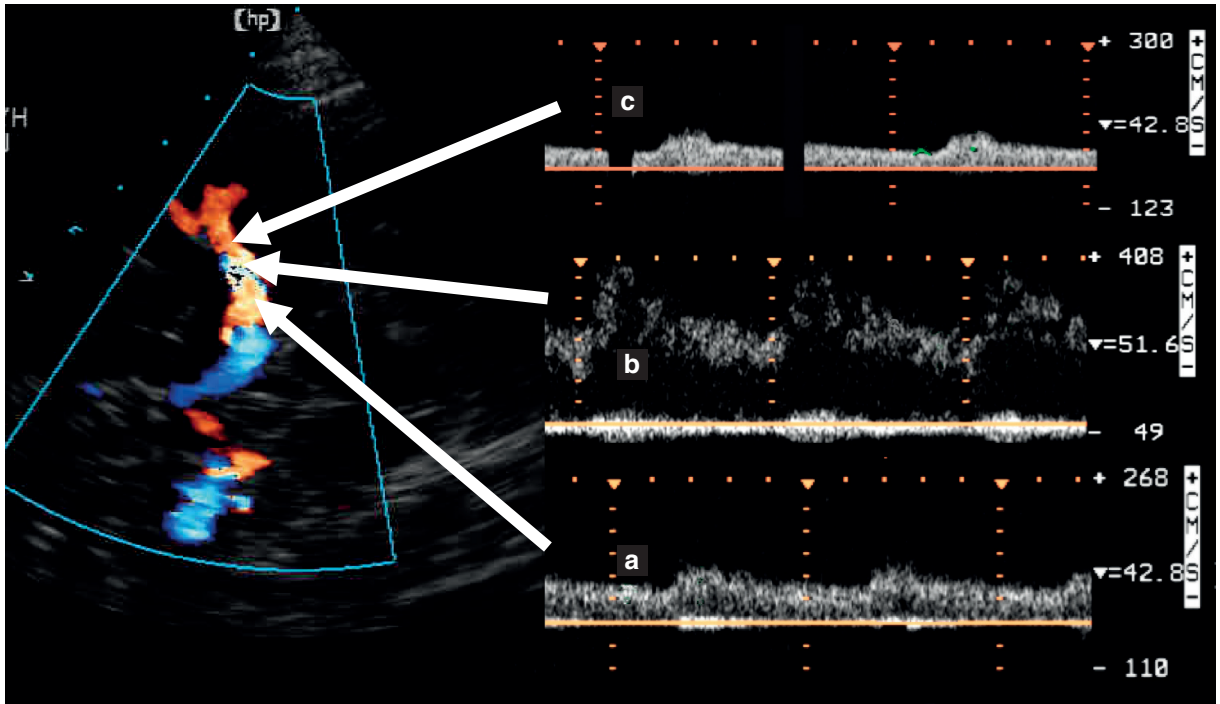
Middle cerebral artery stenosis. (A) Color coded sonography. (B) Doppler frequency spectrum. a = prestenotic; b = intra-stenotic; c = post-stenotic.
